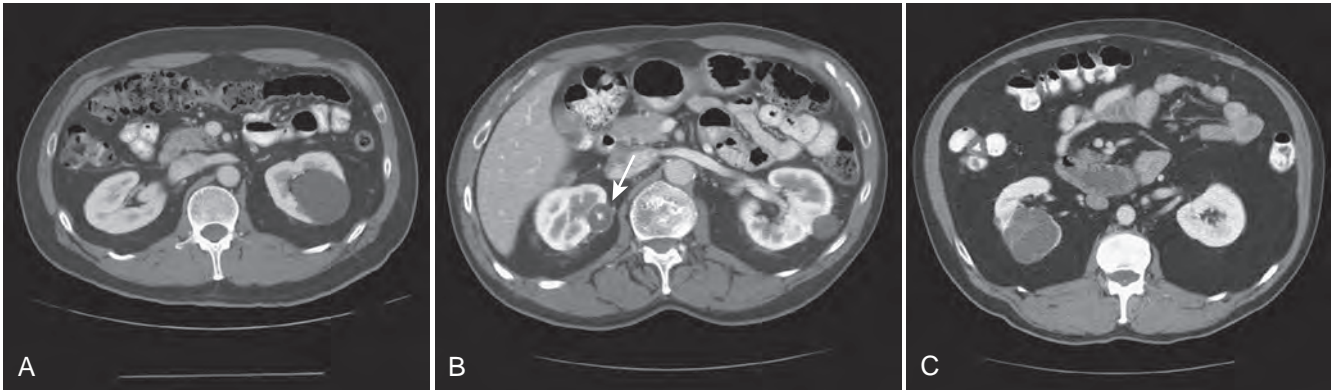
A, Computed tomography (CT) scan of a Bosniak I renal cyst. B, CT scan of a Bosniak II renal cyst. Note internal calcification. C, CT scan of a Bosniak IIF renal cyst. Several thin irregular septations are present within the cyst. (Copyright 2009, C. G. Wood.)
